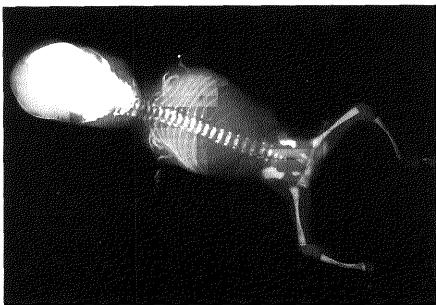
Radiographics of the head show micrognathia, malar hypoplasia and brachycephaly. One pair of ribs and both fibulae are missing whereas both scapulae and ischii are hypoplastic. Severe phocomelia of the upper limbs is present with the humerus, ulna and radius replaced by a single, angulated bone located in the shoulder girdle. Oligodactyly of the upper limbs is present. These radiologic abnormalities are very reminiscent of those of AFD cases described by Rodriguez et al¹.
